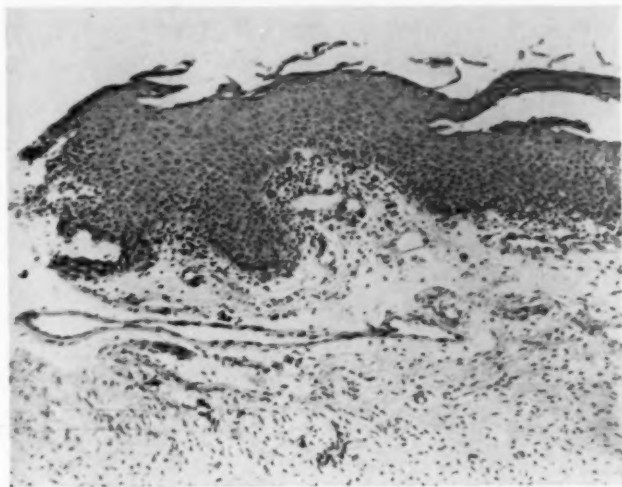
Case 4. 1949. Biopsy of right and left vocal cords yielded tissue of this type interpreted as keratosis. Deep X-ray therapy to larynx in 1952. Recurrences thereafter were limited to one small area of left cord. See Figs. 8 and 9 for tissue taken seven and eight years later.
